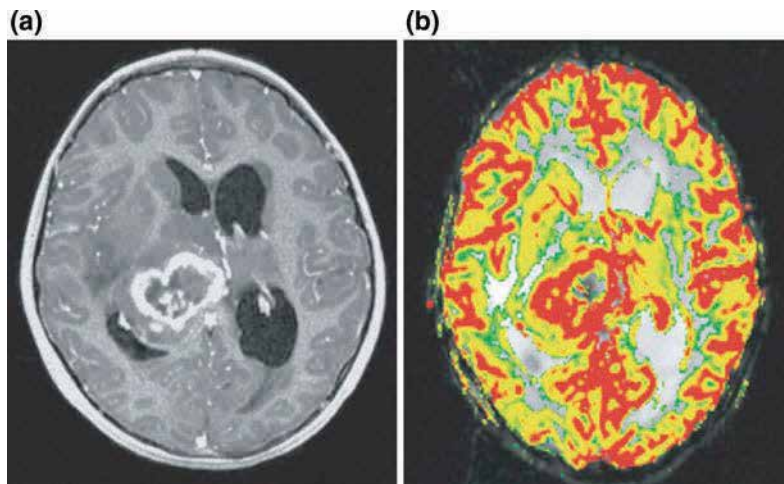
MRI brain post-Gd T1-weighted image (a) showing ring enhancement in the right thalamus and *deep gray* structures with associated mass effect, midline shift, and obstructive hydrocephalus. Pathology was consistent with glioblastoma multiforme. Perfusion MRI (b) shows increased regional cerebral blood flow at the tumor margins.
